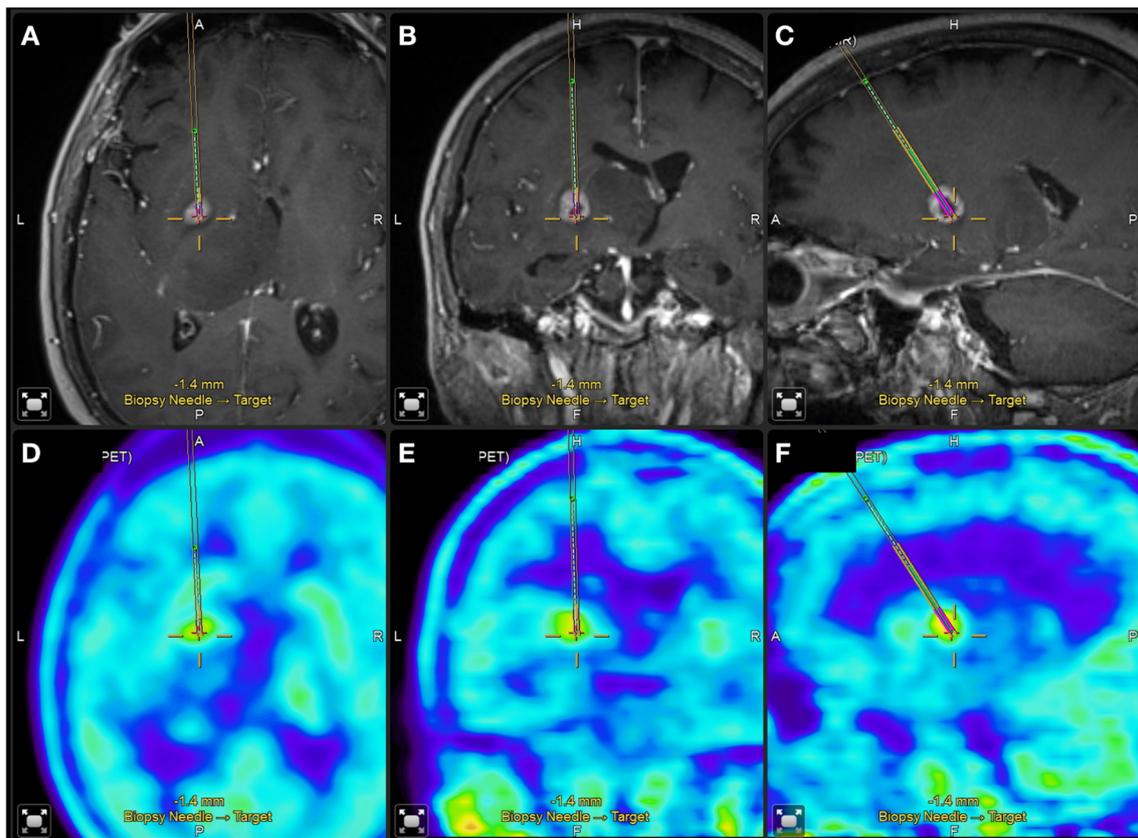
Axial (a), coronal (b) and sagittal (c) post-contrast T1-weighted and 11C-MET-PET CT scans (d–f) are co-registered before surgery and used for trajectory planning. The trajectory is shown (yellow), with the entry point located in the left middle frontal gyrus and the target, a deep presumptive high-grade glioma, located in the basal ganglia area. The sampling window is shown in purple and allows the surgeon to check the part of the lesion is to be taken and analyzed by the pathologist. The
